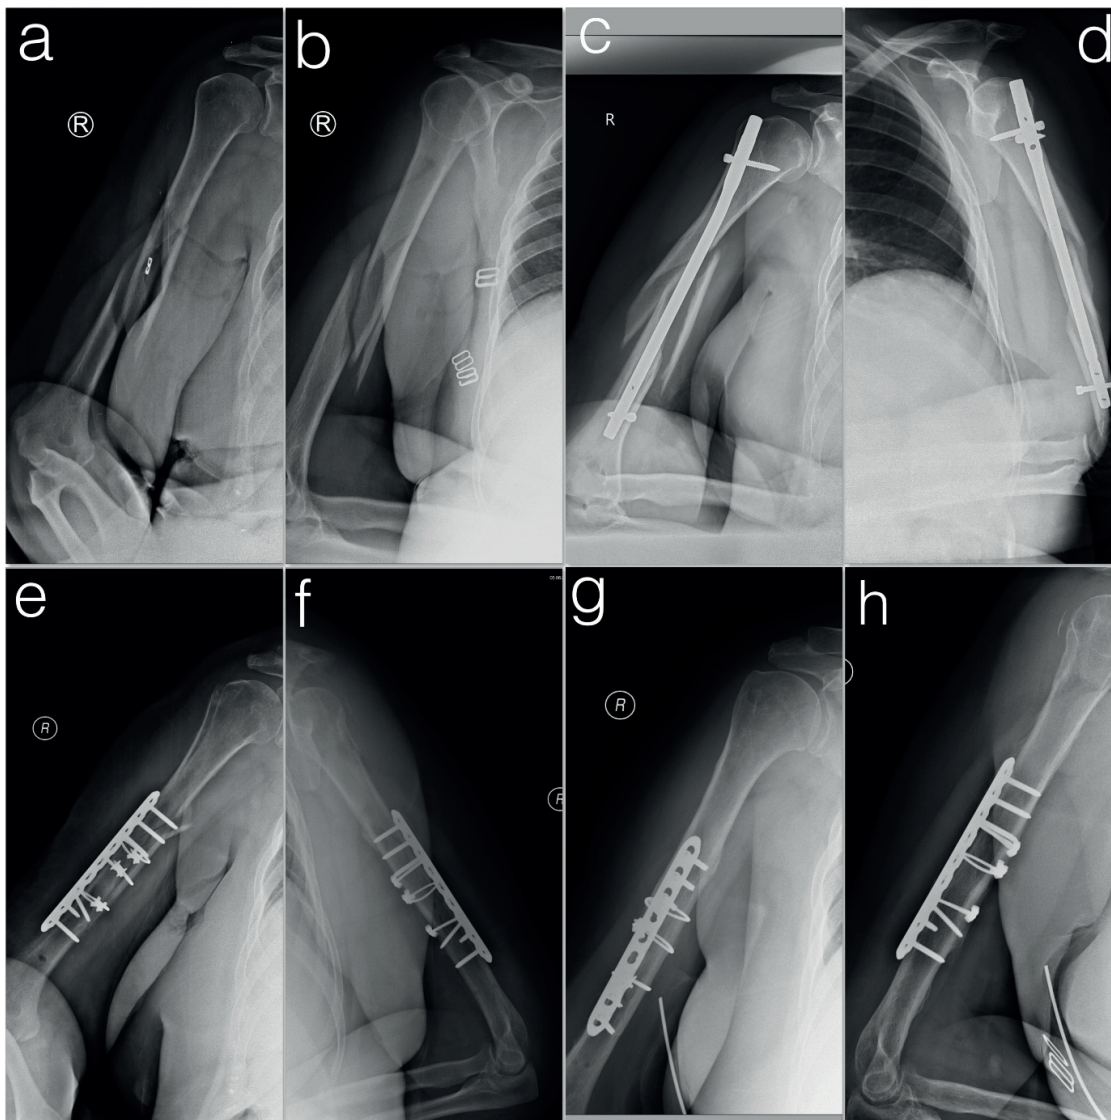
X-rays presenting inadequately chosen primary stabilization technique of middle 1/3 of humeral shaft (a, b) with intra medullary nail (c, d). Revision surgery was conducted within 6 weeks from initial surgery with change of IM nail to LCP plate with cerclage wire (e, f). X-ray 7 months after the surgery with bone healed (g, h)
